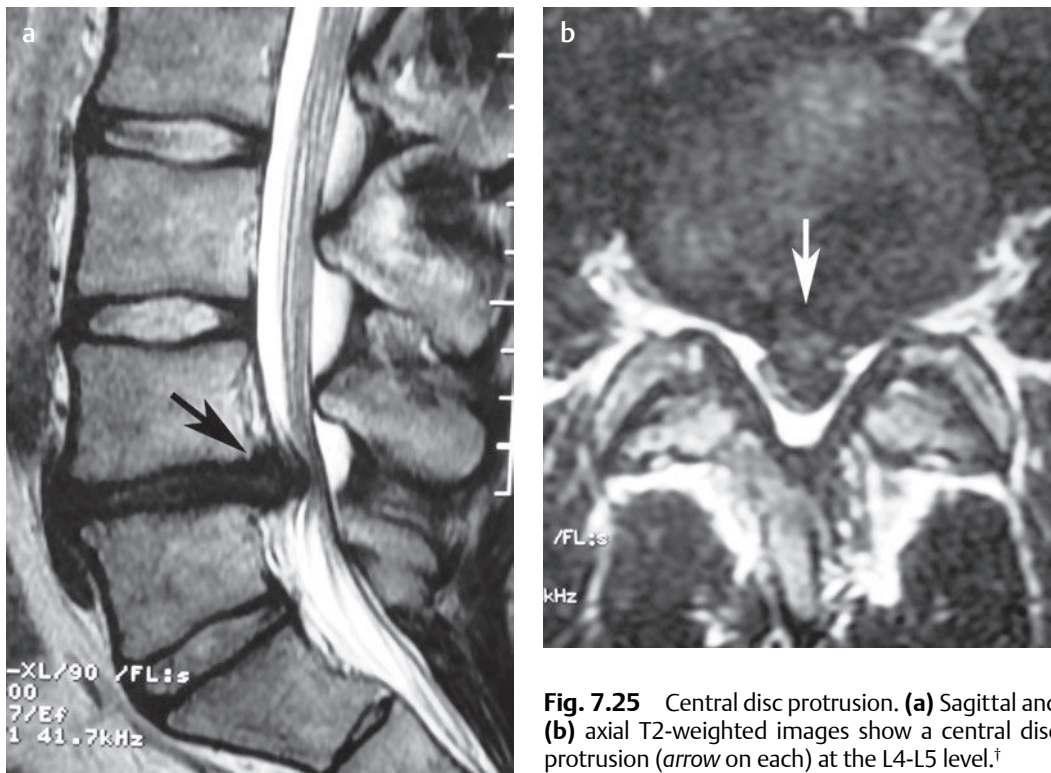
Central disc protrusion. (a) Sagittal and (b) axial T2-weighted images show a central disc protrusion (arrow on each) at the L4-L5 level.[†]
